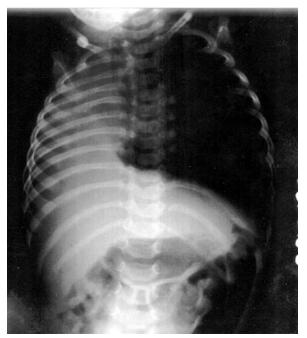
Chest x-ray of the patient showing opacity at the right side of the chest with herniation of left lung to the right. Mediastinum with heart is displaced to the right.
